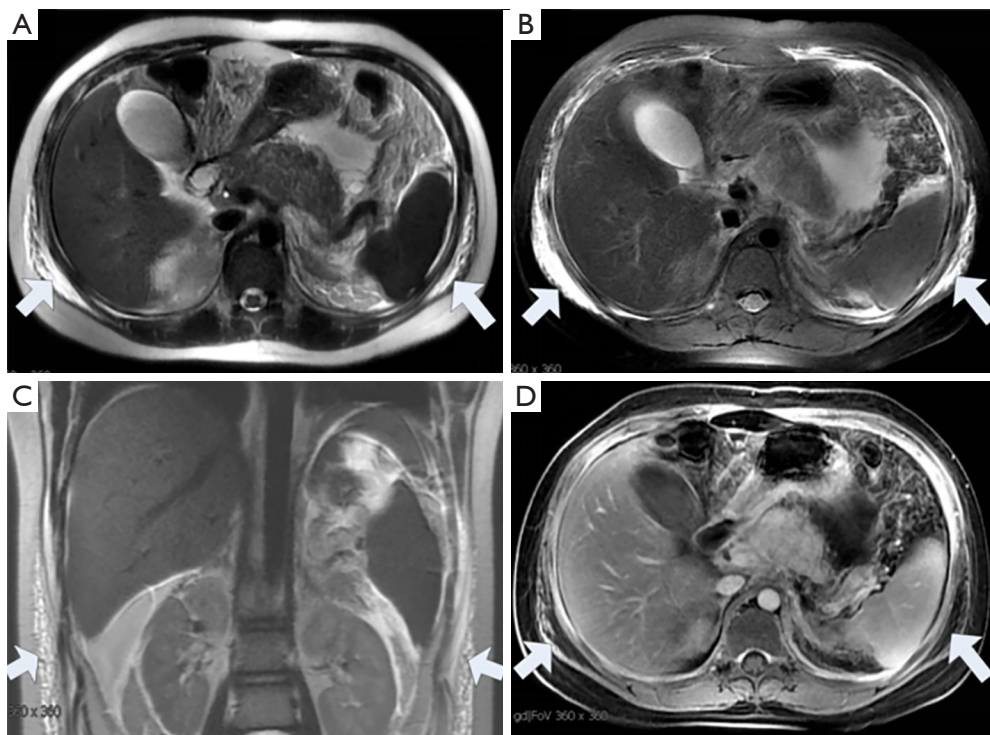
A 38-year-old female with acute pancreatitis. The MRI T2WI (A,C) and fs-T2WI (B) show irregular, patchy, strip-like hyperintense signals, a blurred muscle space and disordered soft tissue structures on both sides of the abdominal wall (arrows). There was no enhancement after contrast injection (D, arrow). MRI, MR imaging.
